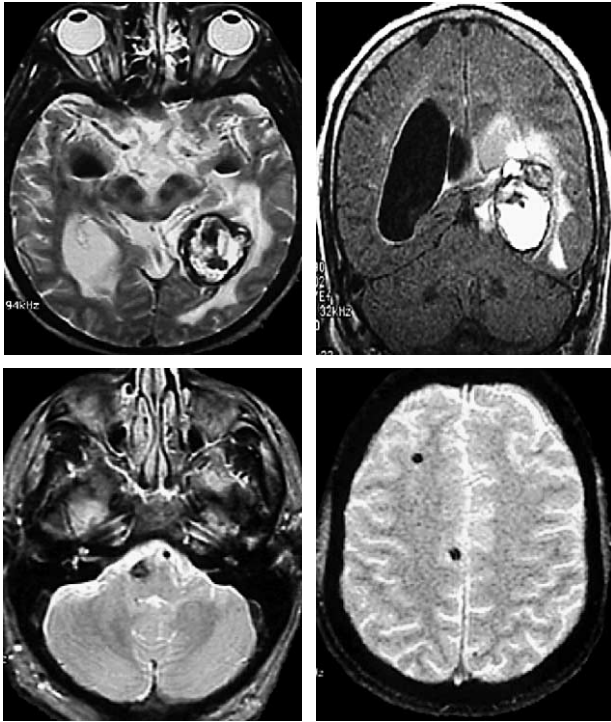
Appearance of CCMs on MRI. From left to right of the upper row, type I CCM and type II CCM. From left to right of the bottom row, type III CCM and type IV CCM.
